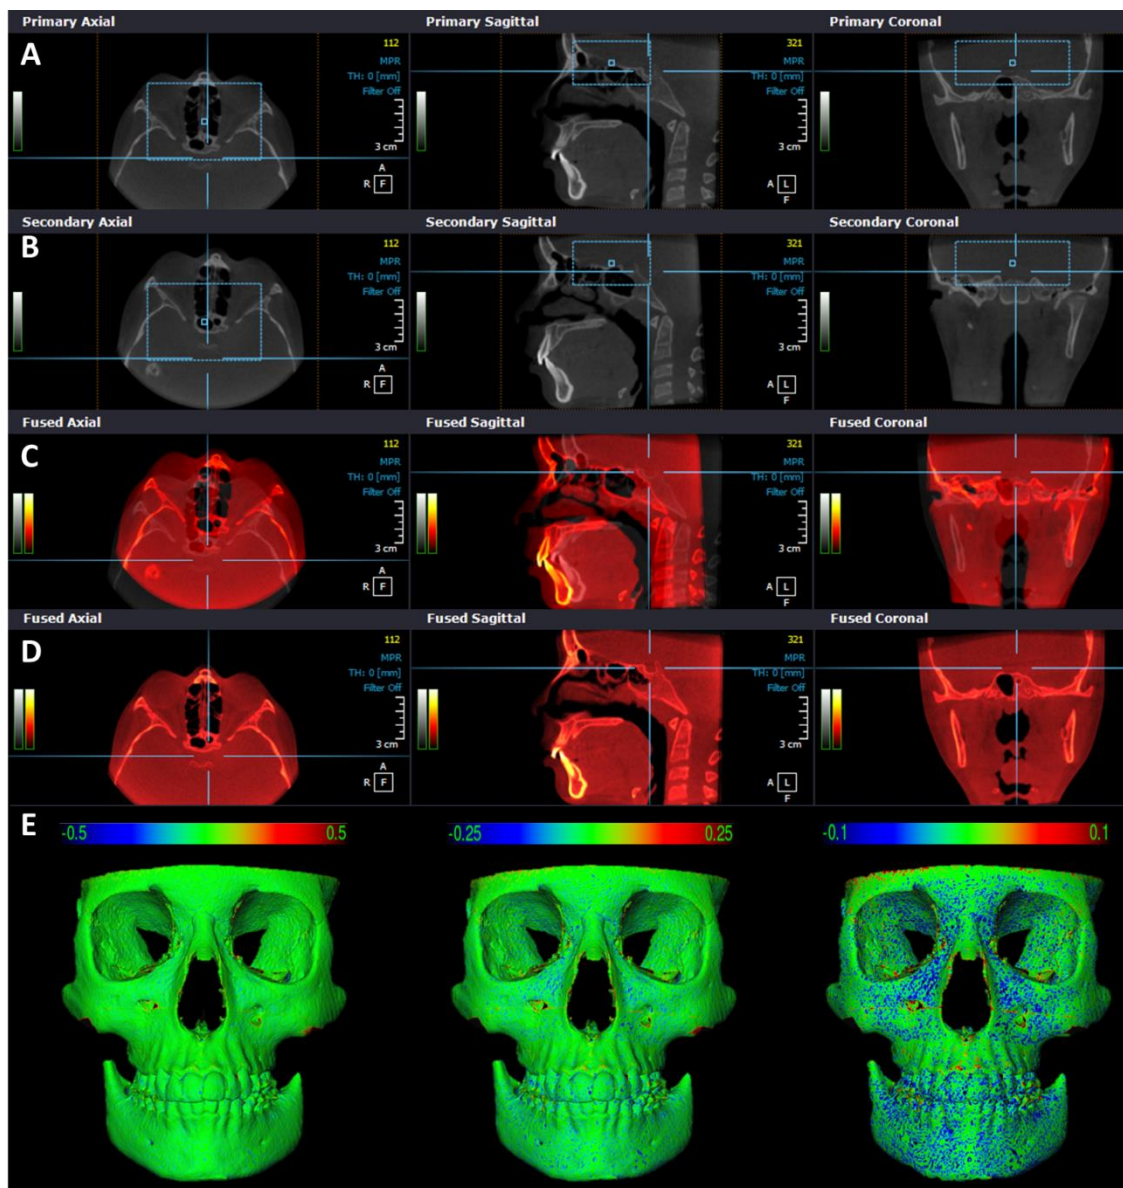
(A) multiplanar slices of original CBCT and (B) reoriented CBCT files, of patient 1, in Ondemand3D. The anterior cranial base was selected (blue rectangle) for superimposition. (C) slices view of CBCT files before cranial base superimposition and (D) after cranial base superimposition. (E) Skull models after superimposition showing 3D displacements (registration error) via color maps with scale of 0.5mm, 0.25mm and 0.01mm. Positive and negative values indicate outward (red) and inward (blue) changes, respectively (CMF application software).
